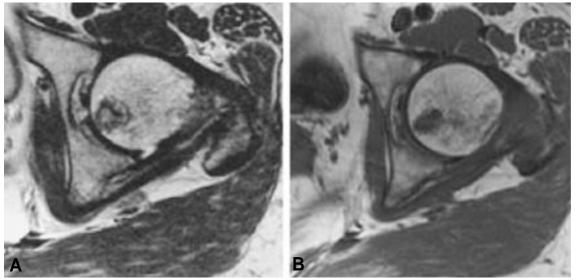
MRI images were taken 3 weeks after therapy, indicating destruction of the previous lesion (A:T1WI, B:T2WI).
